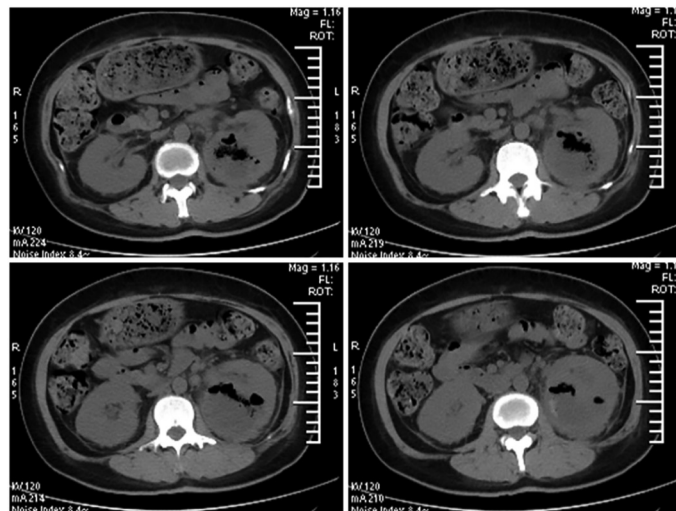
Computed tomography (CT) scan of the abdomen showing a mottled gas collection within the parenchyma of the swelling left kidney.
